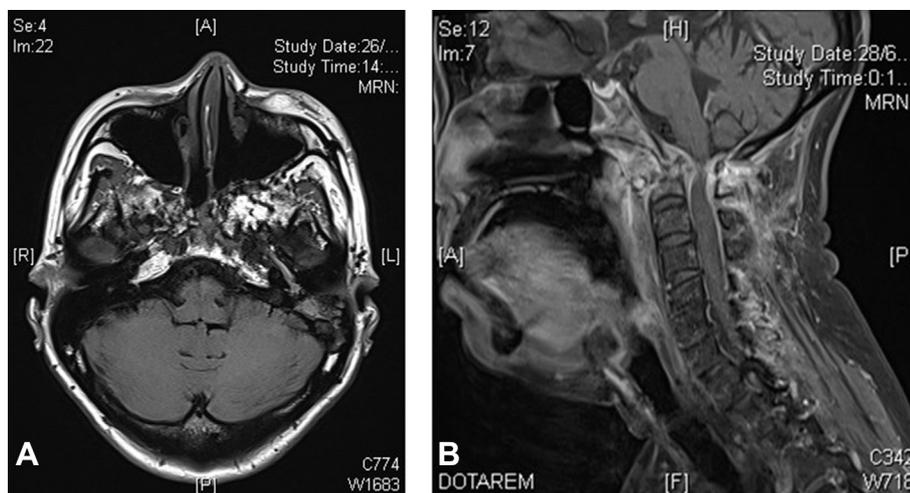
Preoperative magnetic resonance images in (A) axial and (B) sagittal planes showing extensive osteoradionecrosis of the clivus and skull base in a patient previously treated with radical radiation therapy for nasopharyngeal carcinoma.
